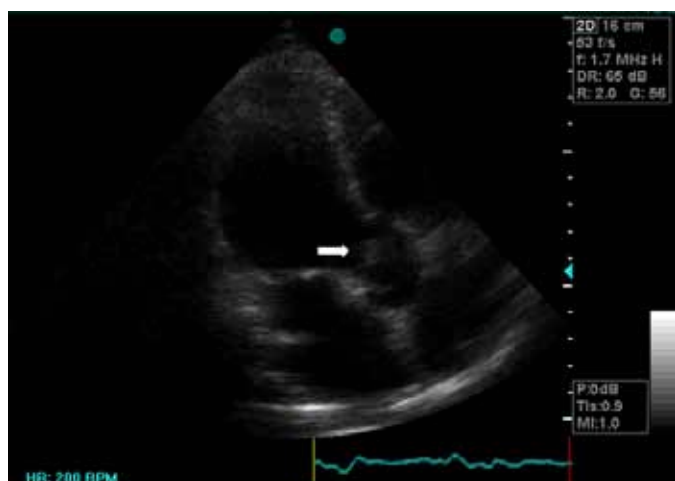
The vegetation on the aortic valve from the apical five-chamber view in the transthoracic echocardiography.
